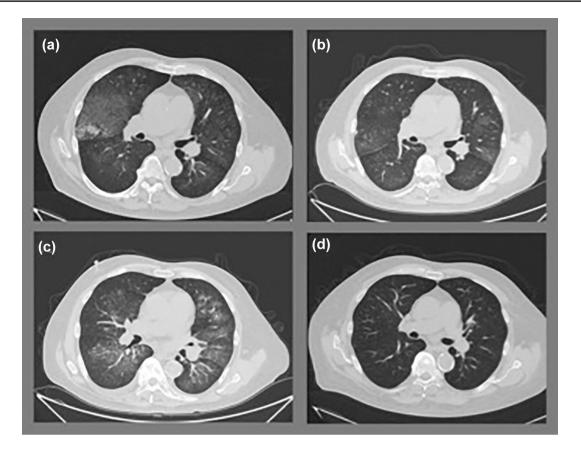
HRCT scan on day 1 (a), day 17 (b), day 20 (c) and at a 2-month follow up (d).
